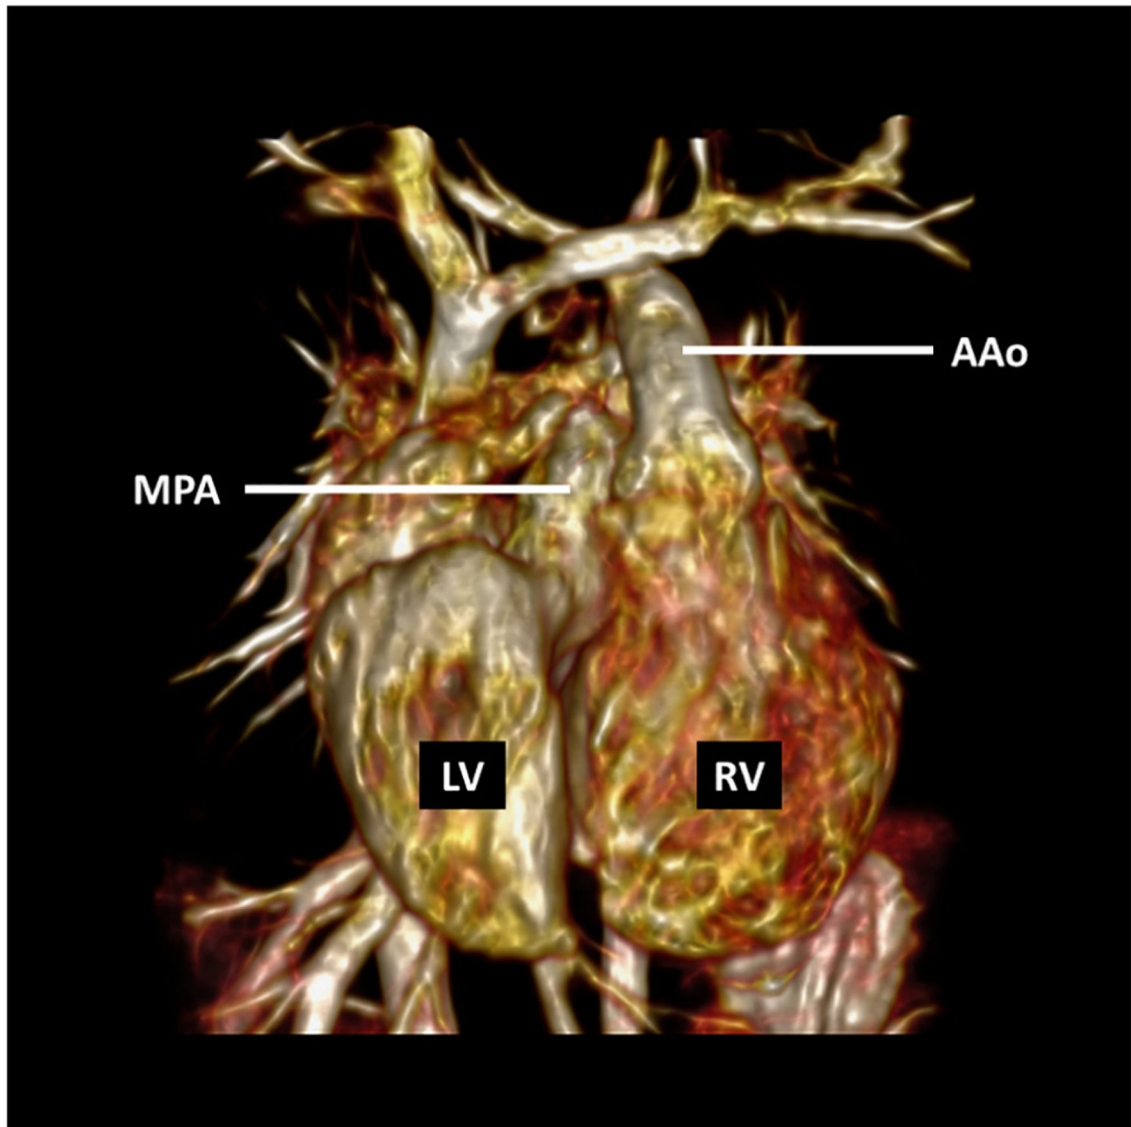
3D Cine Magnetic Resonance Imaging
